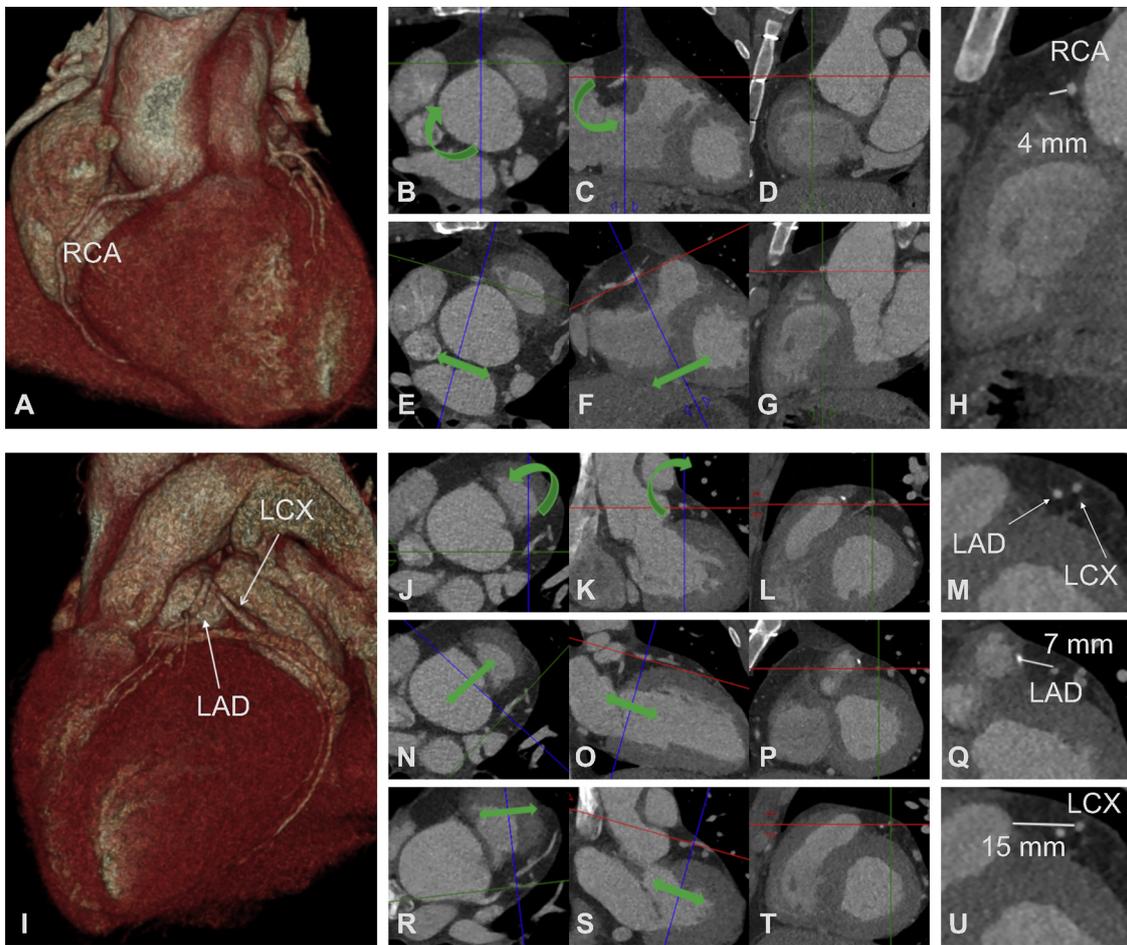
CT Analysis: Relationship between RCA, LAD, LCX and pulmonary trunk (PT). Volume rendering showing a patient who underwent Ross procedure (A, I). Relationship between RCA and PT: initial standard axial (B), coronal (C) and sagittal (D) planes; the center of the imaging crosshairs (that are locked at 90° angles) is placed on the RCA and are rotated (see arrows) to be in-line with the RCA (E, F). The final image is perpendicular to the long axis of the coronary artery (G) and by scrolling through this imaging planes (as indicated by the arrows in E and F) the site with the shortest distance to the stenotic part of the PT (sub-valvular tract of PT) is determined and measured, which in this case was 4 mm (H). Relationship between LAD and PT: initial standard axial (J), coronal (K) and sagittal (L) planes; the planes are rotated to be in-line with the LAD and again in the resulting image plane perpendicular to the long axis of the coronary artery (P) the shortest distance to the PT is then determined by scrolling through these images as indicated by the arrows in N and O and measured (7 mm) (Q). Relationship between LCX and PT: planes already rotated to be in-line with the LCX (R, S) with final image (T) perpendicular to the LCX and distance to PT of 15 mm (U). RCA, right coronary artery; LAD, left descending artery; LCX, left circumflex artery.
